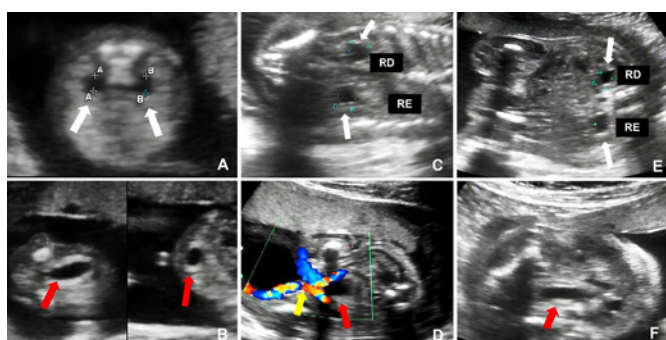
Images of the fetal urinary tract observed through two-dimensional ultrasound at different stages of gestation.
